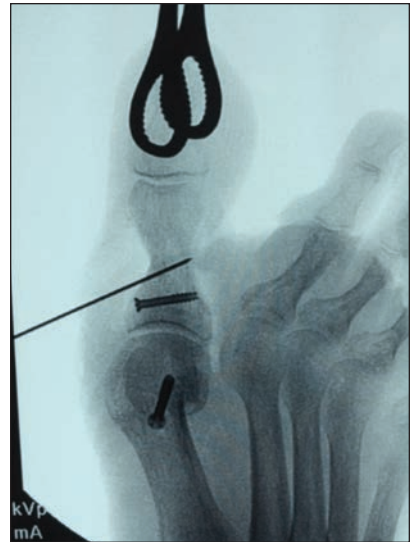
Intra-operative radiographs are used to confirm that appropriate screw length is achieved. Here, a sponge clamp is used to twist the hallux under fluoroscopy for visualization to ensure the guide pin for the cannulated screw exits the far cortex only slightly. Excessively long screws are frequently painful once the patient begins normal ambulation. However, if the screw does not purchase the far cortex, the fixation is likely to fail to maintain stability of the osteotomy.
